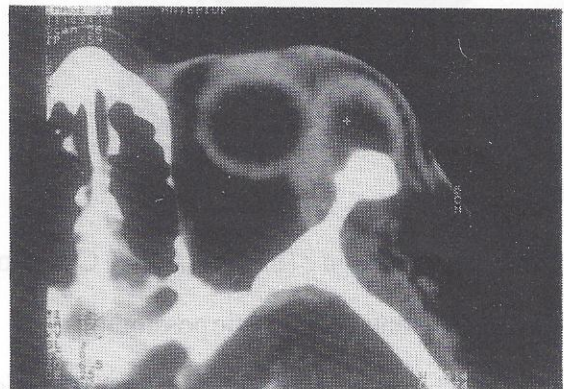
CT scan showing a well demarcated cystic mass in the right anterior orbit.
